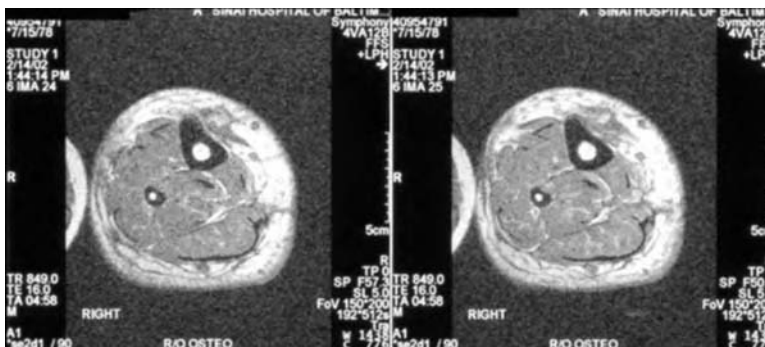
Magnetic resonance imaging findings show isolated, superficial cortical osteomyelitis involvement (as seen in Cierny-Mader stage II).
